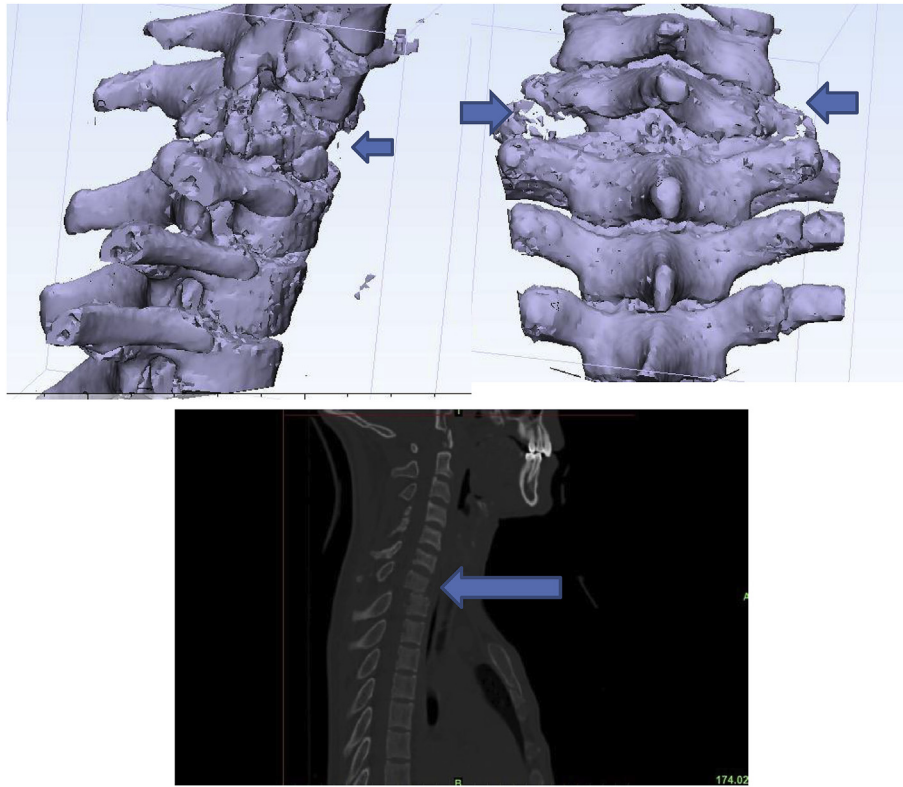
3D RECON and sagittal view of CT scan with arrows showing bifacetal dislocation of C7 over D1.
